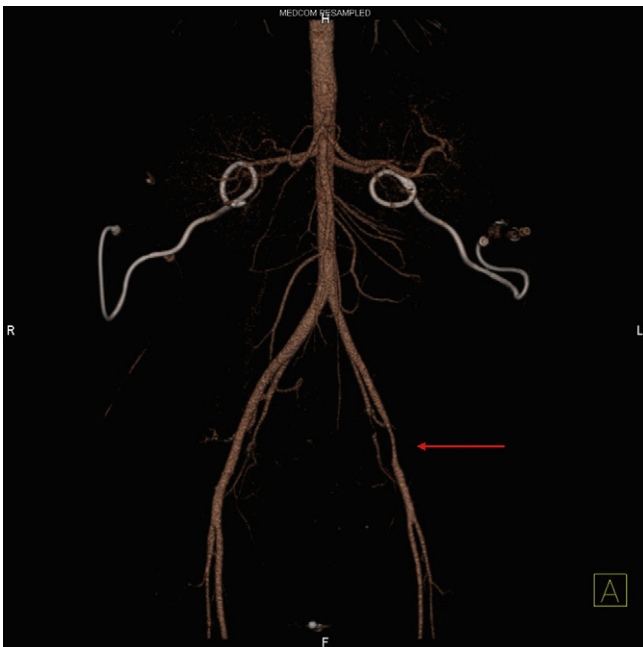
CT angiography reconstruction (patient 6) showing narrowing of the left external iliac artery caused by the tumour (arrow).
